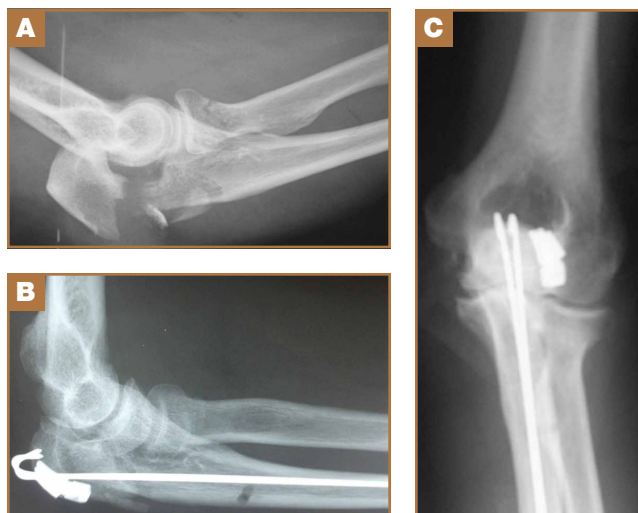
(A) Injury film. (B) Isoelastic tension band construct on anteroposterior radiograph at 3-month follow-up. Note radiolucency of cable and low-profile placement of clamping device. (C) Lateral radiograph at 3-month follow-up.
